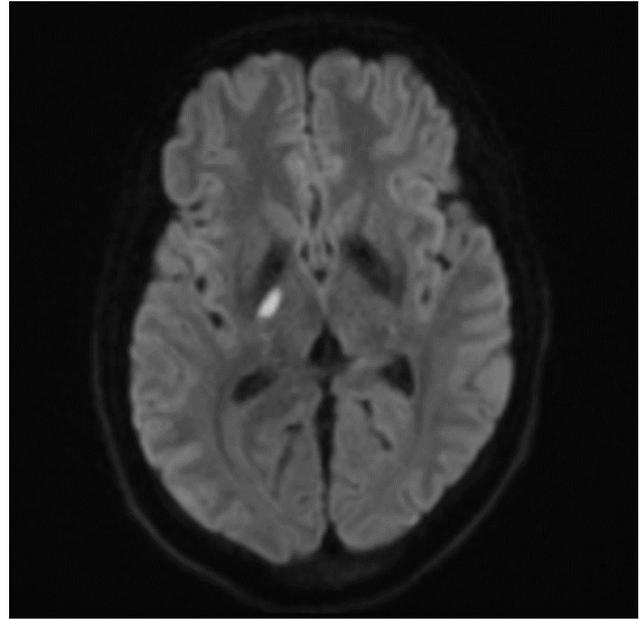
MRI diffusion weighted image showing acute lacunar infarction in right internal capsule
